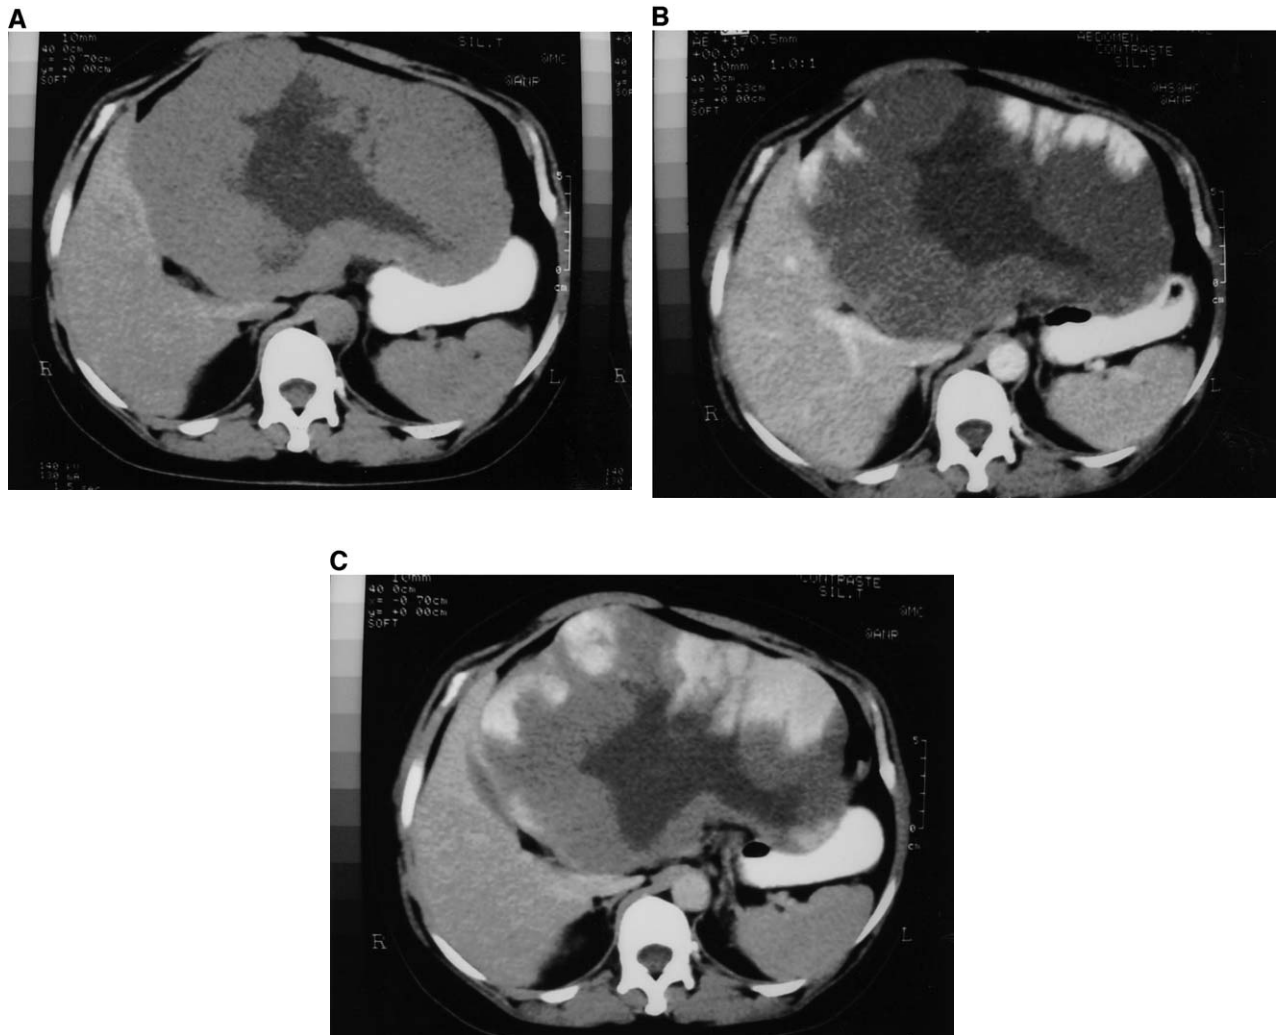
CT scan disclosing (A) a large hypoattenuating mass (20 cm in diameter) in the left lobe of the liver. (B) Peripheral nodular opacification. (C) Centripetal filling and compression of the stomach.
